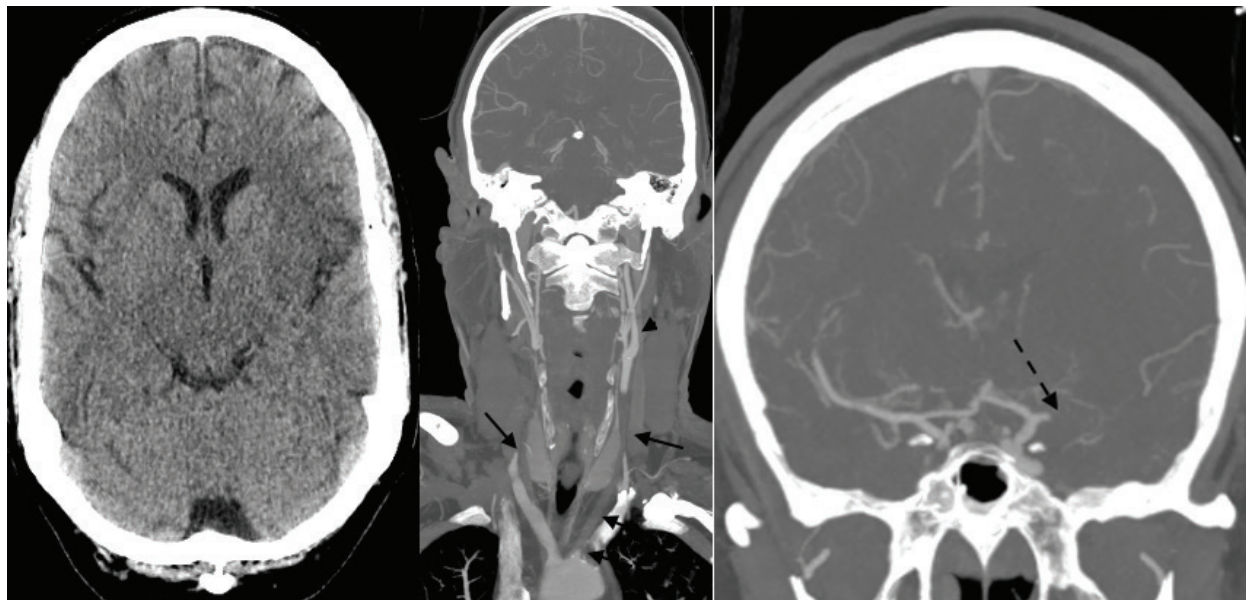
CT of the head showed early infarct signs of loss of gray-white differentiation in the left frontal operculum, insula, and peri-Sylvian cortex. The CTA showed right CCA occlusion and acute left CCA occlusion from its origin (arrows) with reconstitution of the ICA (arrowhead) via ECA collaterals as well as tandem MCA occlusion (dashed arrow).
